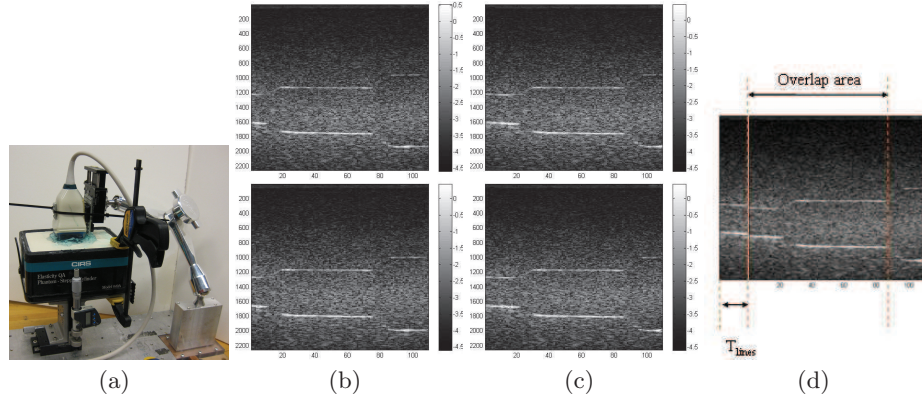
Experimental setup (a). Bmode ultrasound data before and after compression for (b) position t_0 , and (c) position t_1 . Translation T_{lines} and the length of the overlap area are shown in (d).
